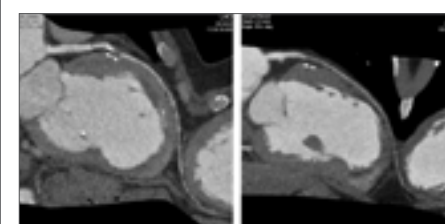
Coronary CTA findings of the two cases of LAD-CTO
